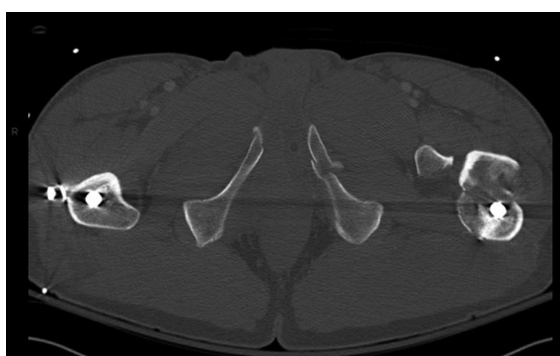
Axial computed tomography scan image showing the fracture at the screw insertion site.
